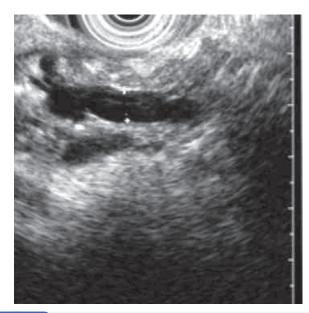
Endoscopic ultrasonography in a patient with chronic pancreatitis, demonstrating a dilated pancreatic duct (*marks* on margin of main duct).
